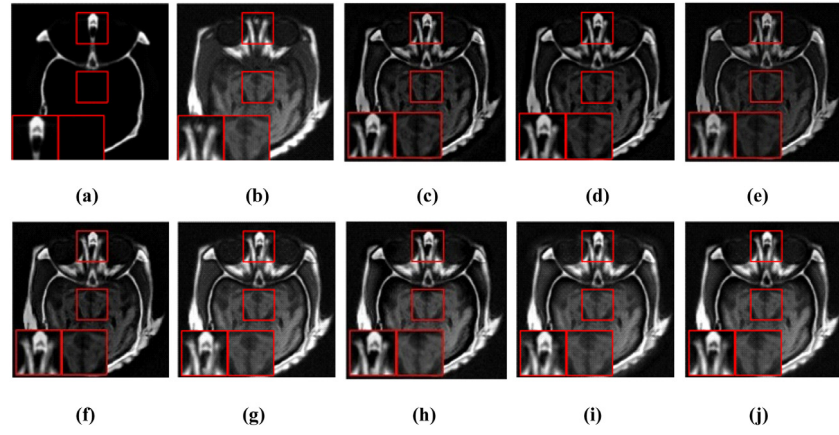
The fusion results of CT and MRI images. (a) CT; (b) MRI; (c) NSST; (d) NSCT; (e) CSR; (f) CSMCA; (g) NSCT-RPCNN; (h) NSCT-SR; (i) NSST-PAPCNN; (j) Proposed.
